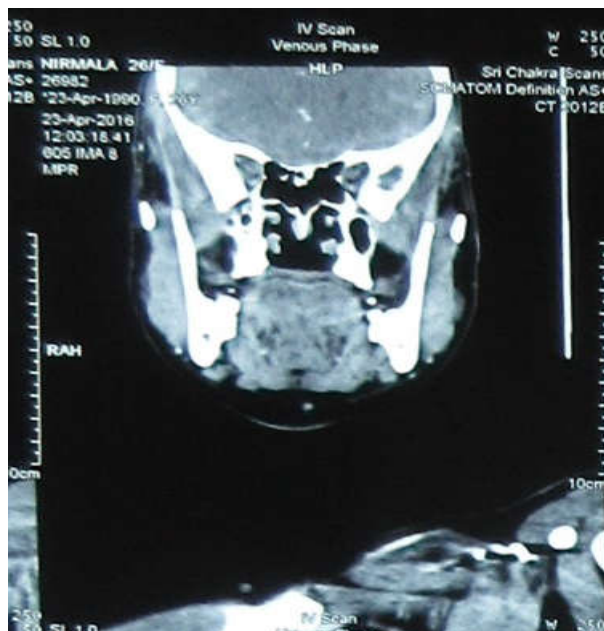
CT Contrast – head and neck (Coronal Section)
